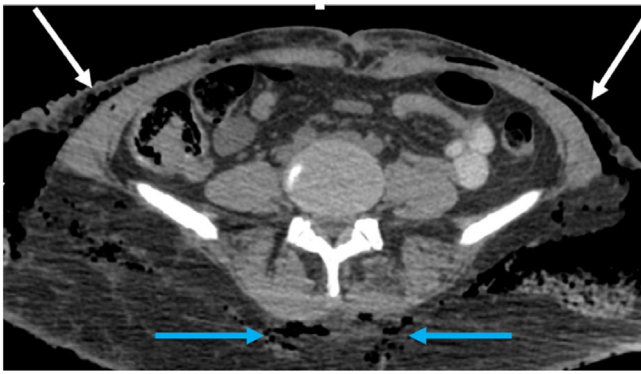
Axial CT scan showing significant gas in subcutaneous soft tissues of the lateral abdominal walls with subcutaneous emphysema (bold arrows) as well as subcutaneous edema surrounding the anterior and posterior abdominal muscles and fascias (thin arrows).
